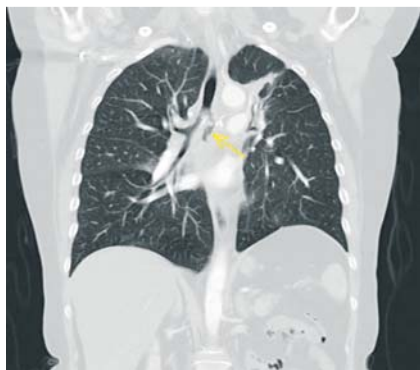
CT of the chest on day 4 after EBUS-TBNA showing pneumomediastinum and mediastinitis.
